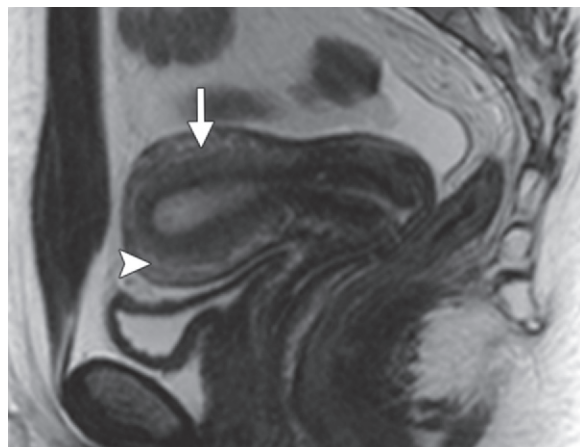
Normal uterine zonal anatomy. Sagittal high-resolution T2-weighted FRFSE MR image shows the normal uterine zonal anatomy. The high-signal-intensity endometrium is surrounded by the homogeneous low-signal-intensity junctional zone (arrow), which is continuous with the fibrous cervical stroma. The myometrium (arrow-head) has intermediate signal intensity and is contiguous with the outer interstitial cervical stroma.
